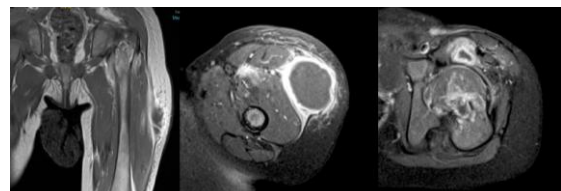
Left Hip MRI showing collection and OM changes
